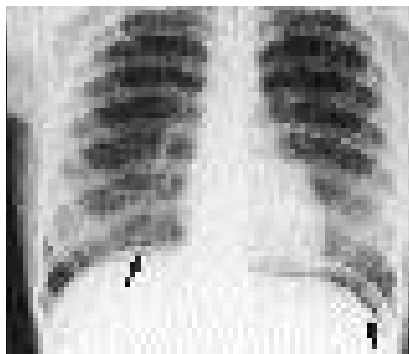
Erect chest X-ray showing free air under both hemi-diaphragms.
